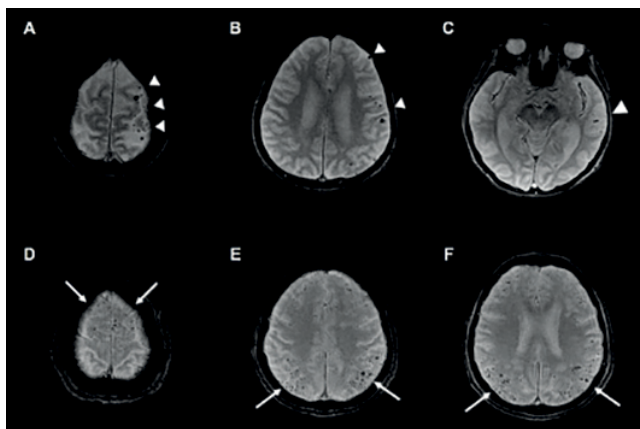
1.5T axial brain MRI, T2* GRE sequences showing multiple strictly lobar cerebral microbleeds (CMB) supporting the diagnosis of probable cerebral amyloid angiopathy. A-C: A 77-year-old patient (CMB=arrowheads); D-F: A 83-year-old patient (CMB=white arrows).
